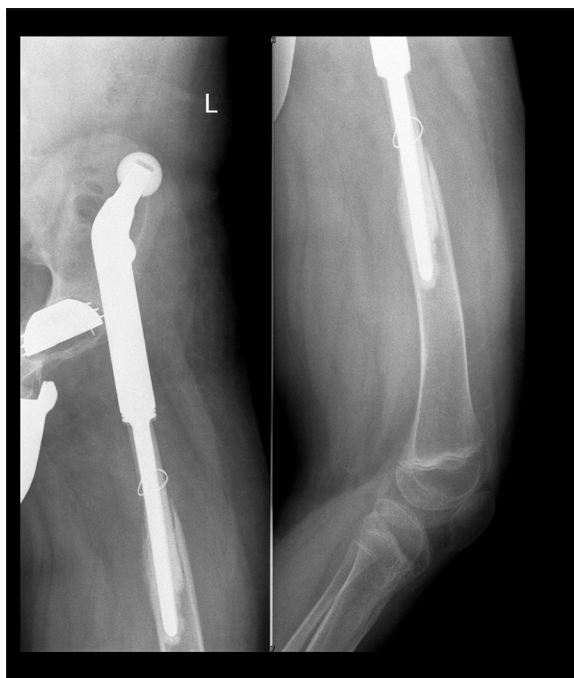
19-year-old boy with femoral chondrosarcoma one year after implantation of hip endoprosthesis. X-ray: joint dislocation.
